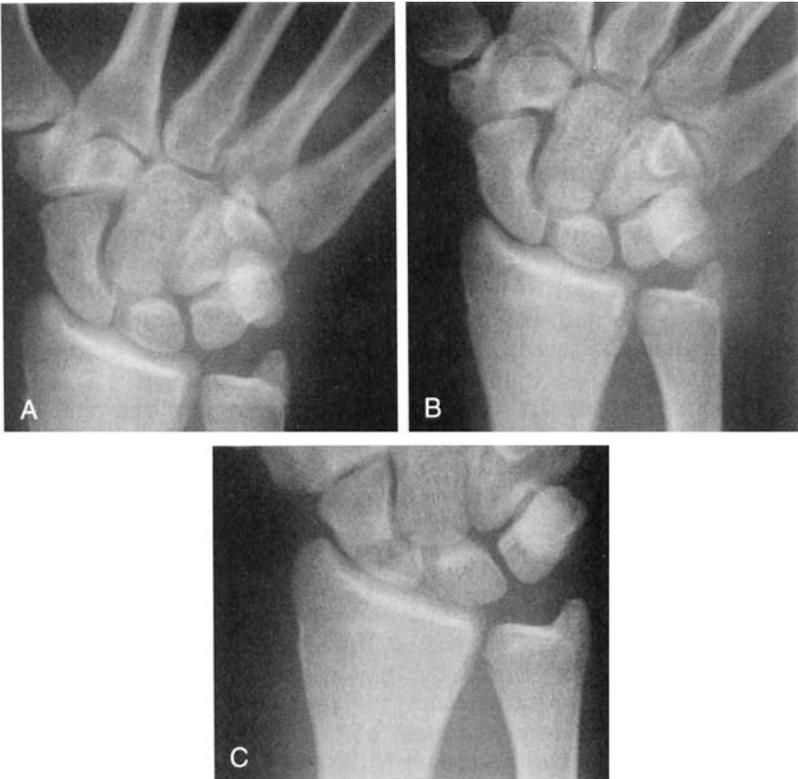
A, Anteroposterior (AP) radiograph in ulnar deviation of a 17-year-old linebacker with hyperextension injury to the wrist and acute snuffbox tenderness. Patient is placed in a thumb-spica playing cast because a fracture of the scaphoid is not apparent on radiographs. B, Two-weeks postprocedure with continued snuffbox tenderness. Repeat radiographs do not reveal a fracture. Thumb-spica immobilization continued. C, Patient does not return for follow-up despite several attempts. Patient finally returns for follow-up radiographs at 6 weeks, revealing a fracture of the proximal scaphoid.
